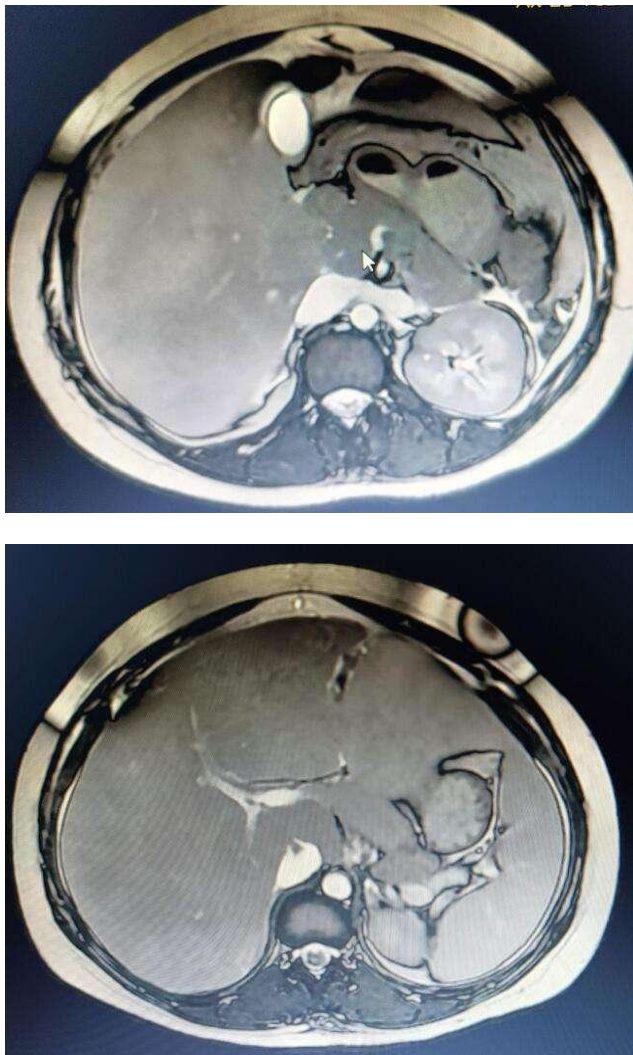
Axial T2-weighted MRI showing hepatomegaly, ascites, and altered signal within portal structures suggestive of thrombosis
